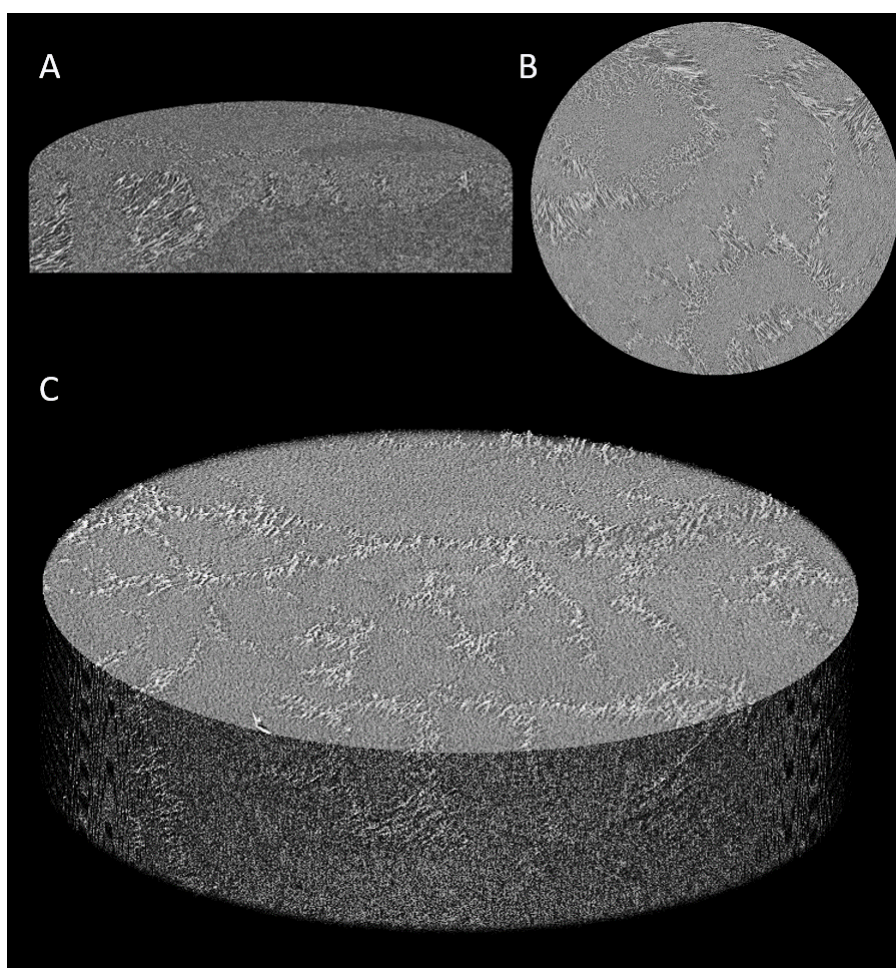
Micro CT scans of a 10% PVA aerogel showing (a) a three-dimensional representation of an orthogonal slice through the scanned section (b) a cross section of the scanned section of the gel and (c) a full three-dimensional representation of the scanned portion of the gel.
